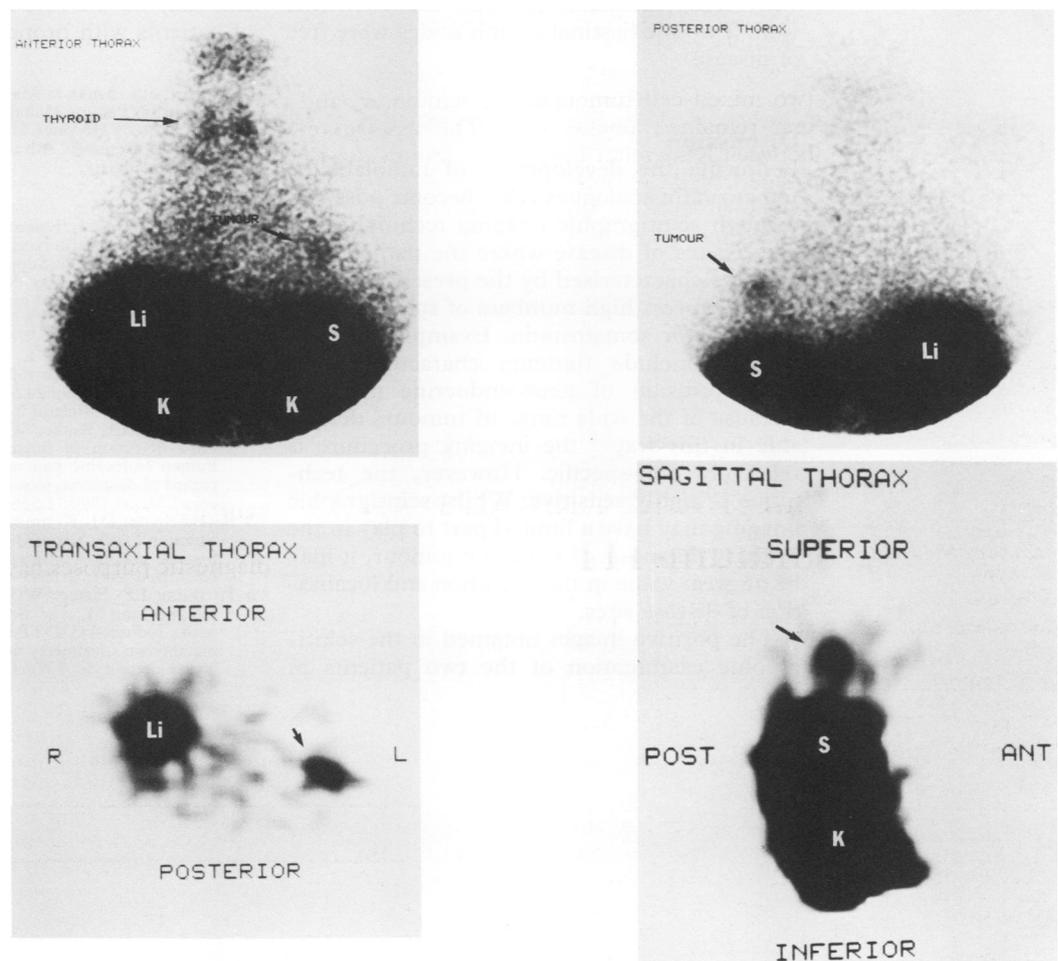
The images in A and B represent anterior and posterior planar acquisitions of the thorax in case 1. Pathological accumulation of the radiolabel is seen at the base of the left lung. The images in C and D represent SPECT acquisitions of case 1. The transaxial (equivalent to a computed tomographic image) and sagittal (a lateral view through the tumour) images shown here demonstrate uptake of the radiolabel (arrows) in keeping with the known site of the carcinoid tumour in the lingula, thereby improving anatomical localisation of the disease. Physiological uptake is noted in the liver (Li), spleen (S), and kidneys (K).
